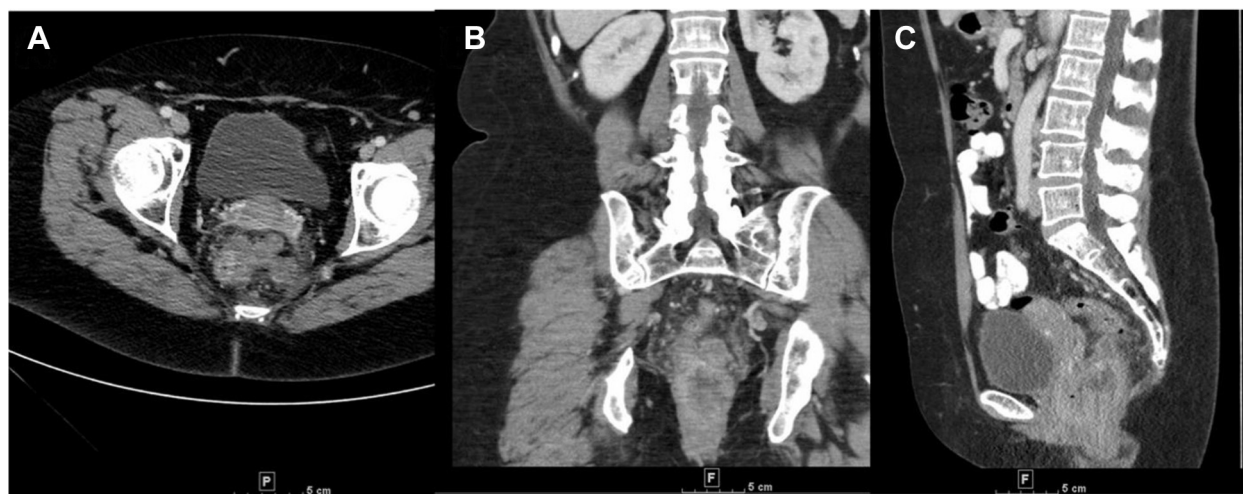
Initial staging computed tomography (CT) with contrast (A = axial, B = coronal, C = sagittal).
